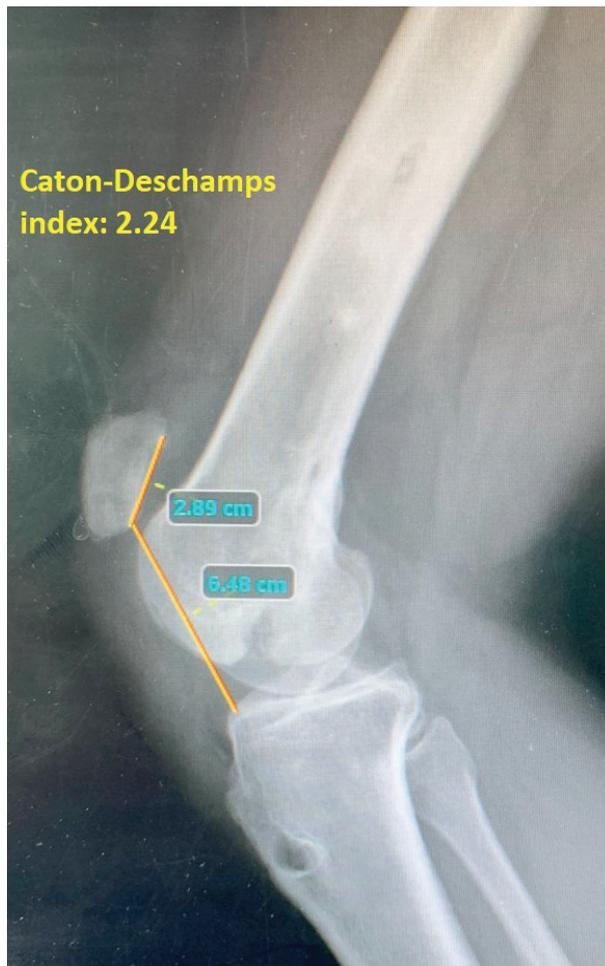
Latero-lateral x-ray of the right knee; Caton- Deschamps index: 2.24
